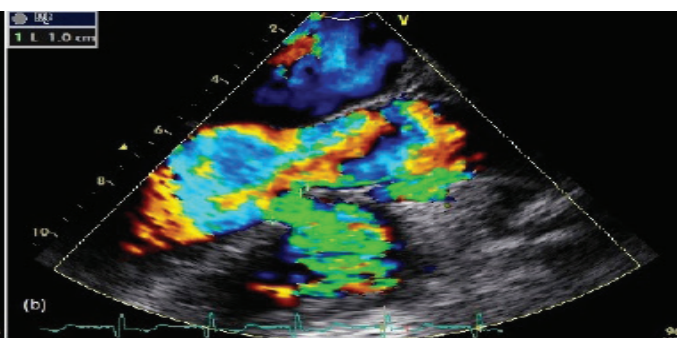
Color Doppler image showing 10-mm ventricular septal defect causing turbulent flow.
